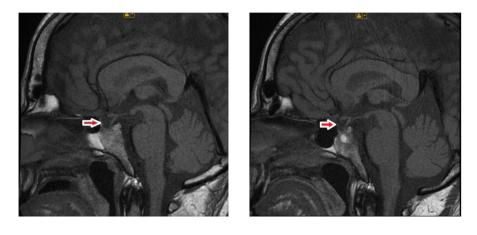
Magnetic resonance imaging (MRI) of the hypothalamic– pituitary region revealed the presence of partial empty sella. Sagittal projection T1 of Patient 1 and Patient 2.
